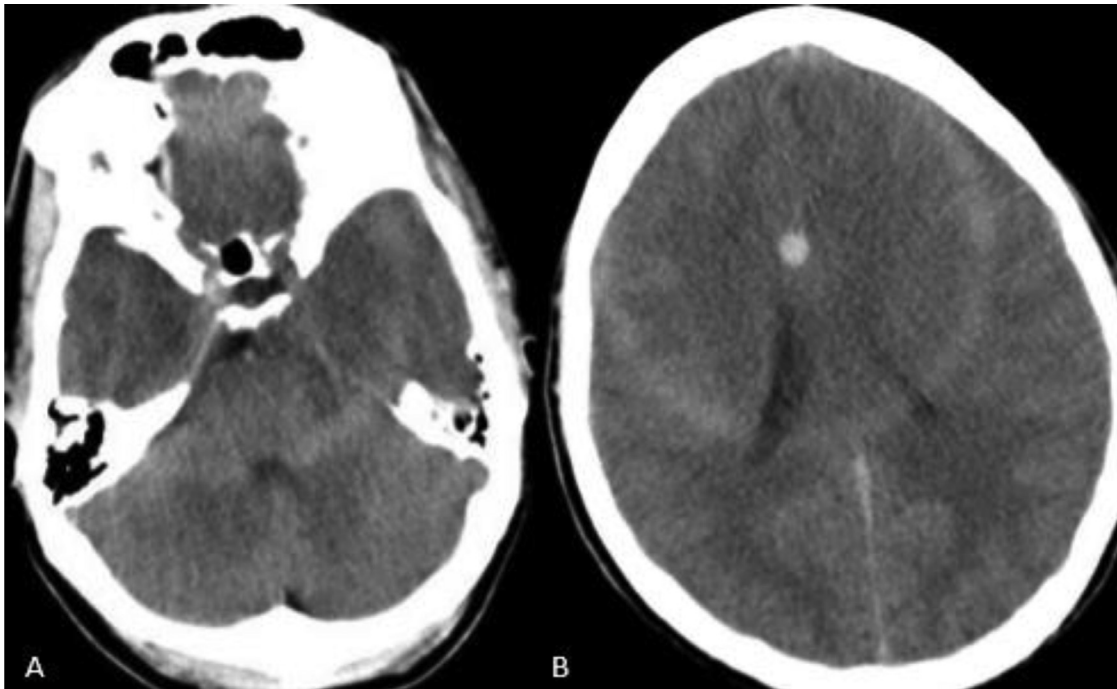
Brain CT scan. Hypodensity and loss of gray-white matter differentiation in bilateral temporal lobes (A), white matter hypodensity in bilateral occipital lobes (B). There is a ring artifact in the images.
